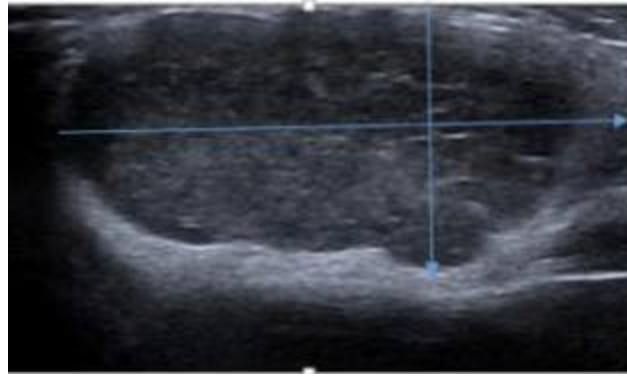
ultrasound image of the size of focal lesion in parotid gland Grayscale measure (19x10 mm)
